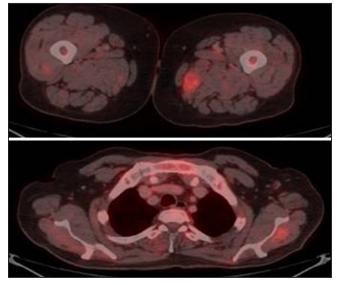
Transaxial fused 18 - FDG PET CT images show FDG uptake in peripheral enhancing hypodense lesions involving left sartorius muscle with SUVmax 4.9 and left infraspinatus muscle with SUVmax 2.9
